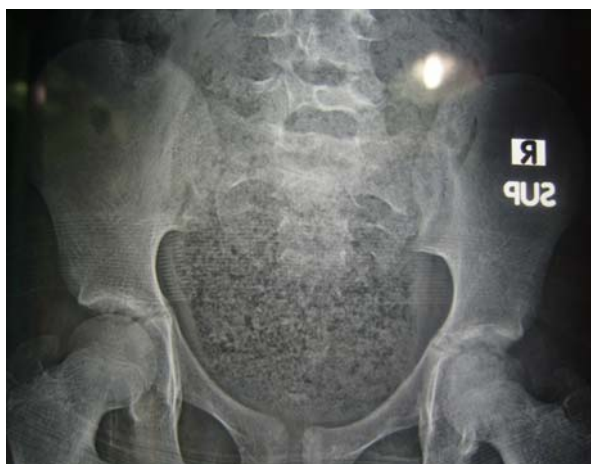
A Plain X-ray showing fecaloma in the rectum
